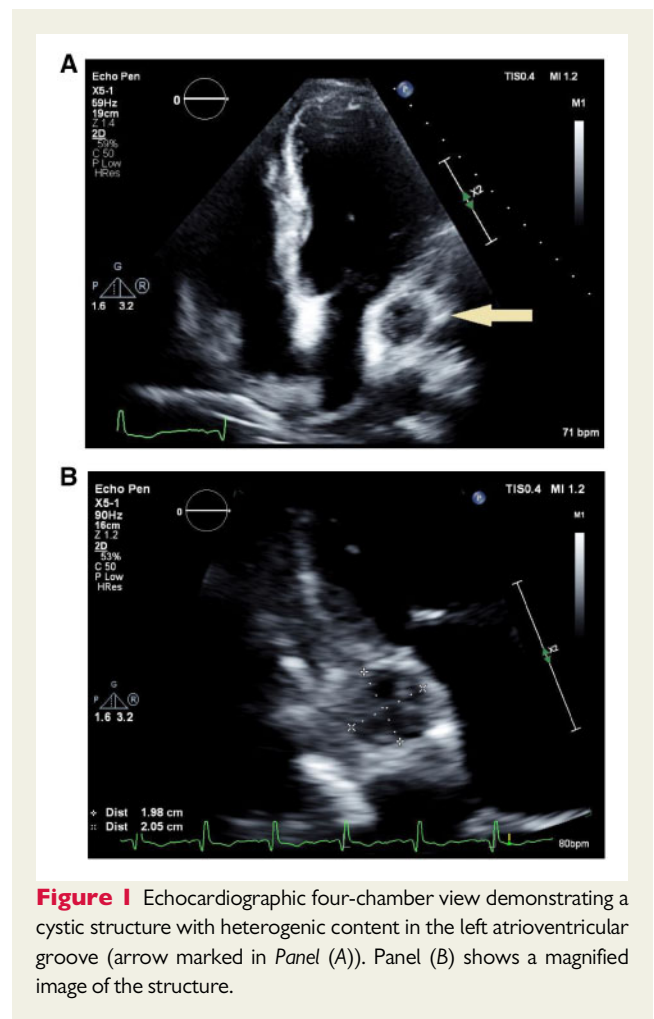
Echocardiographic four-chamber view demonstrating a cystic structure with heterogenic content in the left atrioventricular groove (arrow marked in Panel (A)). Panel (B) shows a magnified image of the structure.
